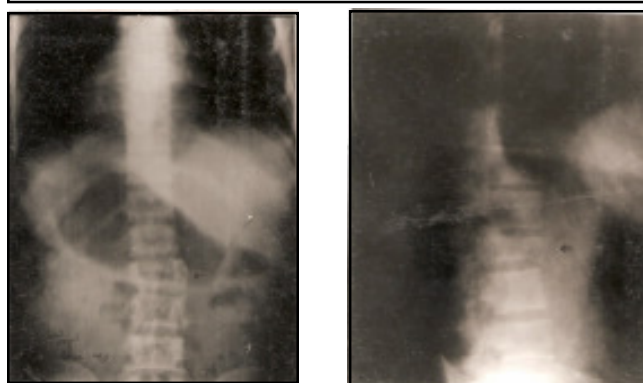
Preoperative AP & Lateral X-rays Showing L2 Fracture
